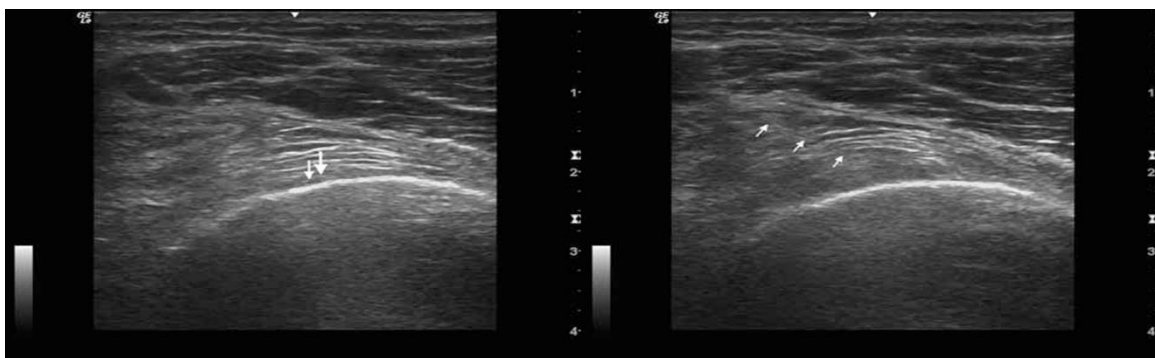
(a) Transverse ultrasound image of the knee at the level of the femoral medial epicondyle. Superior medial genicular nerve (thick arrow) and the corresponding artery (thin arrow) were visualized. (b) The needle (arrows) was placed to the bony cortex 1 cm anterior to the peak of the adductor tubercle for the superior medial genicular nerve (Kesikburun et al., 2016).
